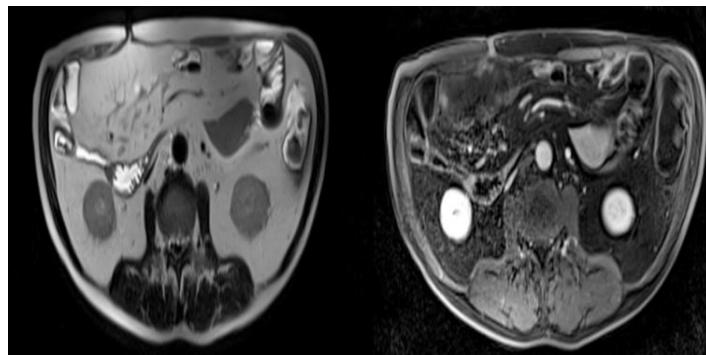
Post-treatment axial T2-weighted TSE MR sequence (A) demonstrating complete disappearance of the mass with only residual irregularity of the right anterior abdominal wall profile; post-treatment axial T1-weighted VIBE MR sequence (B) after contrast administration showed only faint contrast enhancement of the trans-muscular fistulous tract of the right anterior abdominal wall.
